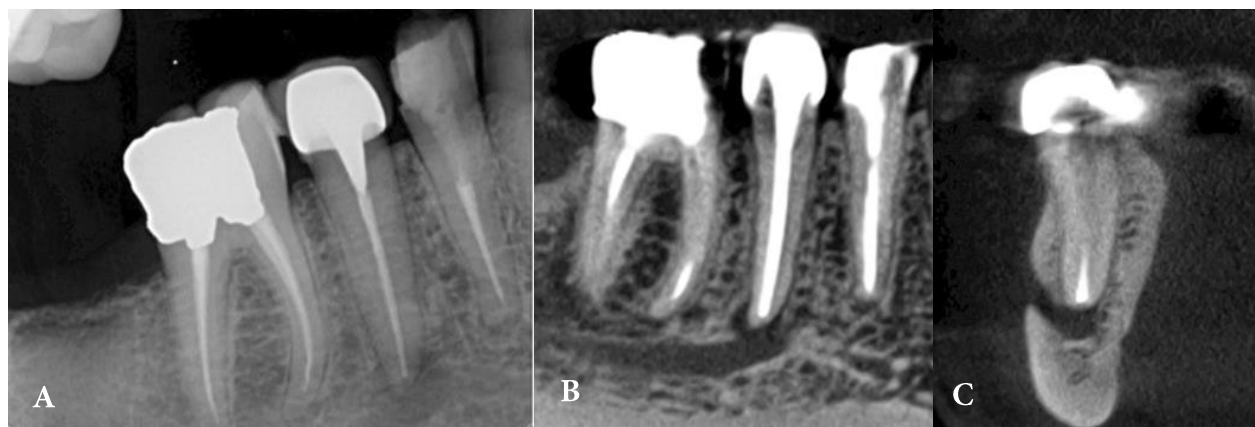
A) Preoperative periapical radiograph of the right mandibular second premolar; B and C) Sagittal and coronal views of mandibular second premolar, the proximity of the second premolar root apex to the neural canal is clearly seen in all three radiographs
